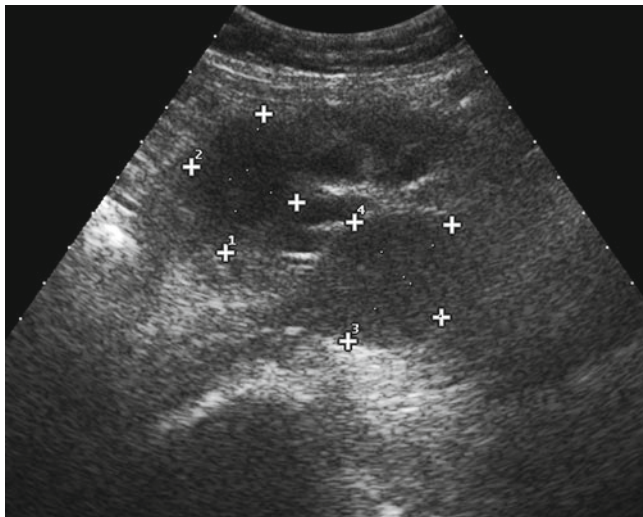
Iliac recurrence after inguinal radical lymphadenectomy. The ultrasound image obtained using an abdominal, low-frequency probe shows two hypoechoic, iliac lymphadenopathies (34 × 26 and 36 × 30 mm)
